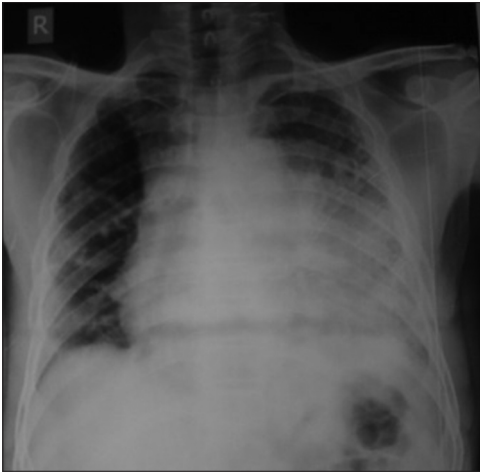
Chest radiograph showing mass in the anterior mediastinum with silhouetting of the left border of the heart
